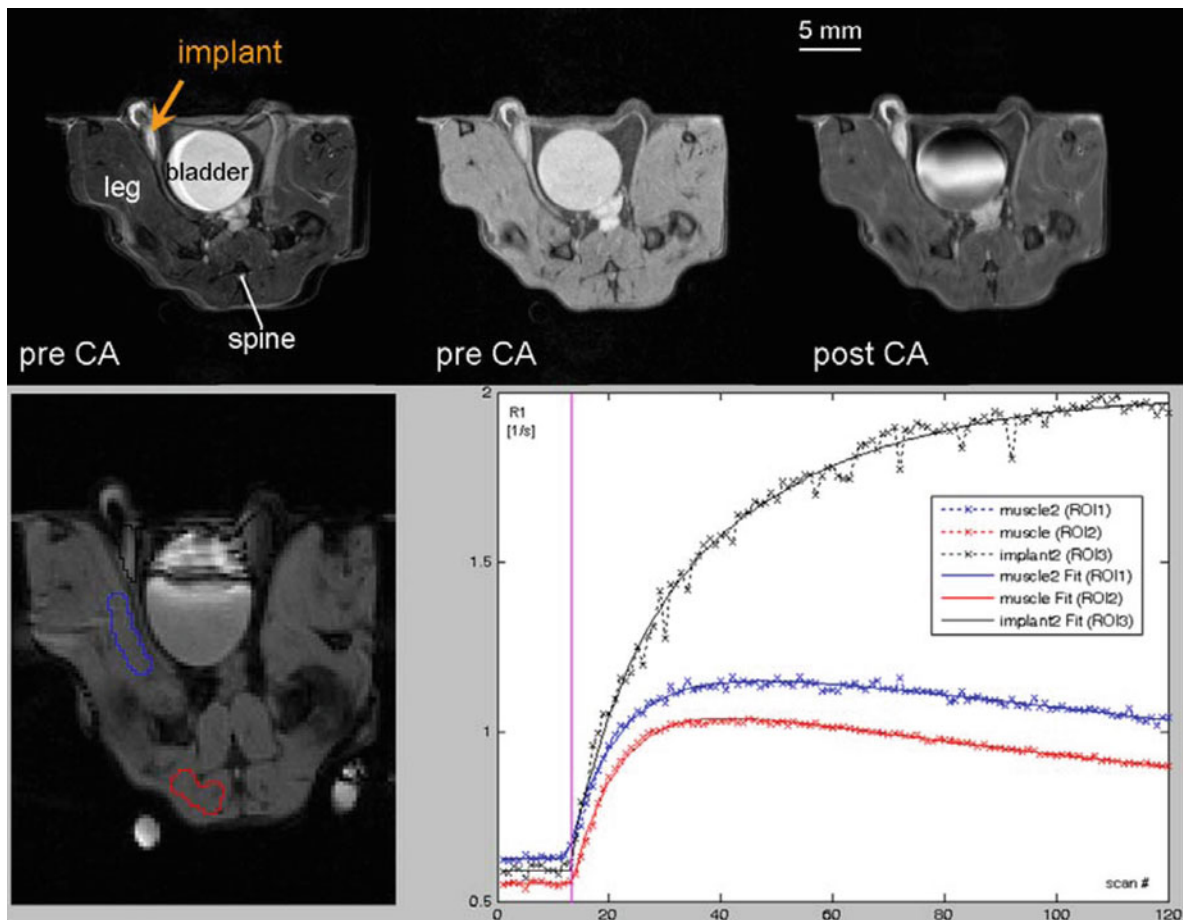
Anatomical MR images of Matrigel plugs in vivo. *Top row:* T₂-weighted axial MR image acquired prior to contrast agent (CA) injection showing the implanted matrix plugs (orange arrows, T₁-weighted axial MR image acquired after CA injection. (in-plane spatial resolution 0.1 mm). *Lower row:*
